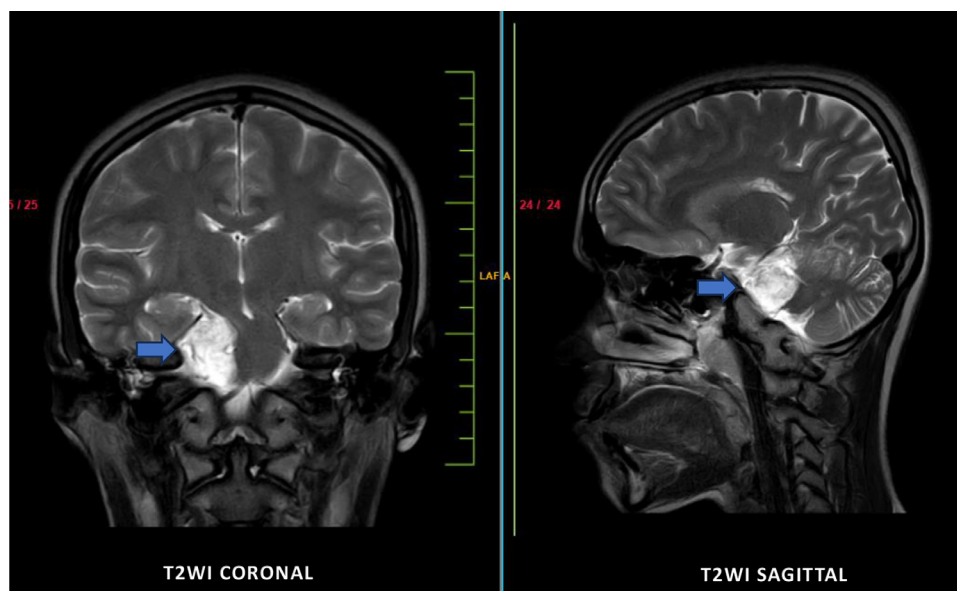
MRI Brain Coronal and Sagittal T2WI showing hyperintense lesion in the right cerebellopontine (CP) angle cistern.
